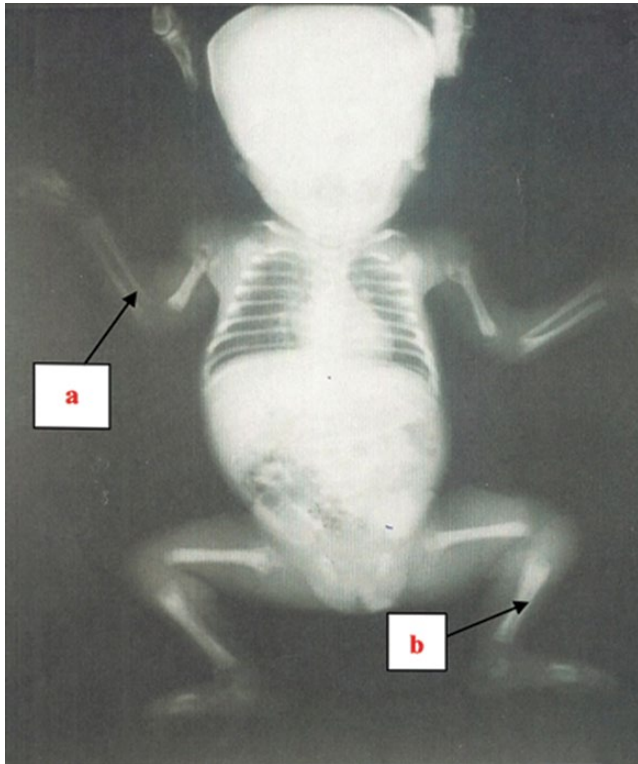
Anteroposterior radiograph of a preterm infant with congenital syphilis demonstrating osteoarticular lesions (a,b) and an enlarged liver. (From Megnier-Mbo *et al.* 2014 [24]. Reproduced with permission of Megnier-Mbo *et al.* and Scientific Research Publishing Inc.)
